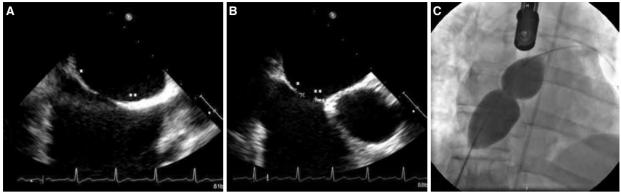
Transesophageal echocardiograms showing a small atrial septal defect with adequate margins for deployment of a percutaneous closure device: (A) *superoposterior rim=2 cm, inferoposterior rim=1.8 cm; (B) *posterior rim=1.68 cm, superoanterior rim=0.4 cm. (C) Balloon measurement of the defect. The indentation at the centre of the balloon defines the stretched diameter as 12 mm.
